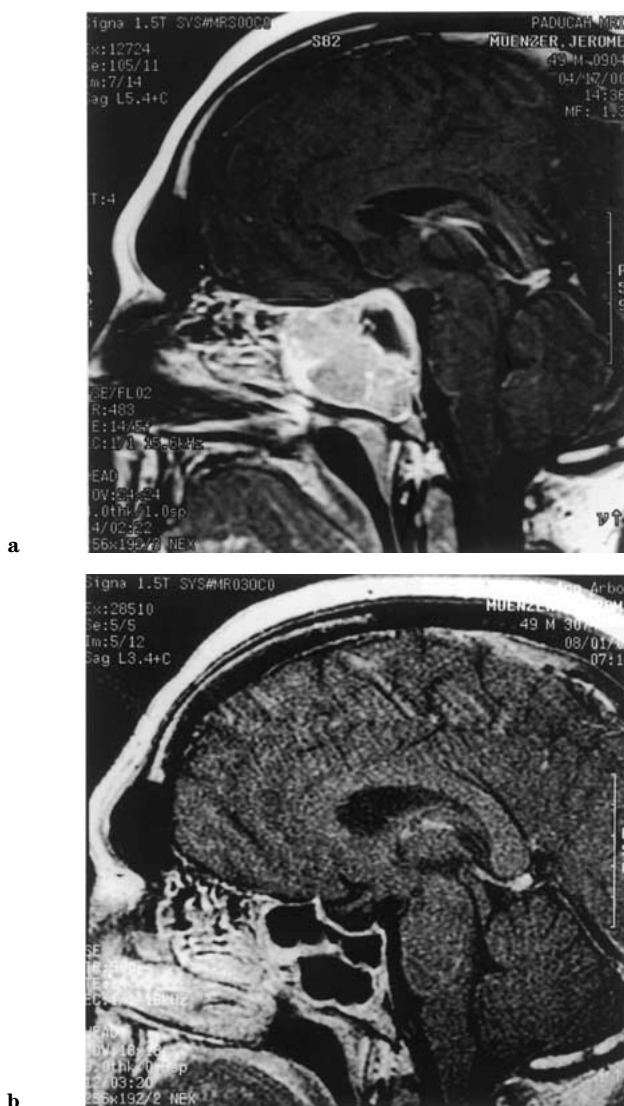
Sagittal gadolinium-enhanced T1 weighted pituitary magnetic resonance image before (a) and 3 months after (b) pergolide therapy (patient 22). Figure 1a shows a 4.1 × 3.5 × 4.1-cm sellar mass with suprasellar and sphenoidal sinus extension with cystic and hemorrhagic components. Fig. 1b shows complete disappearance of the mass with normal appearance of the pituitary gland.
